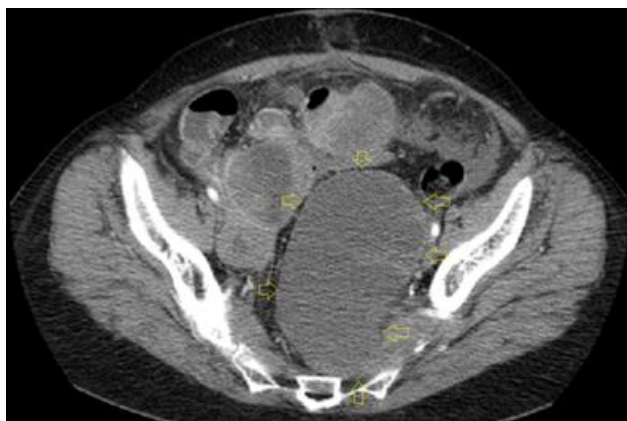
Axial CT of malignant peripheral nerve sheath tumor (recurrence lesion indicated)
